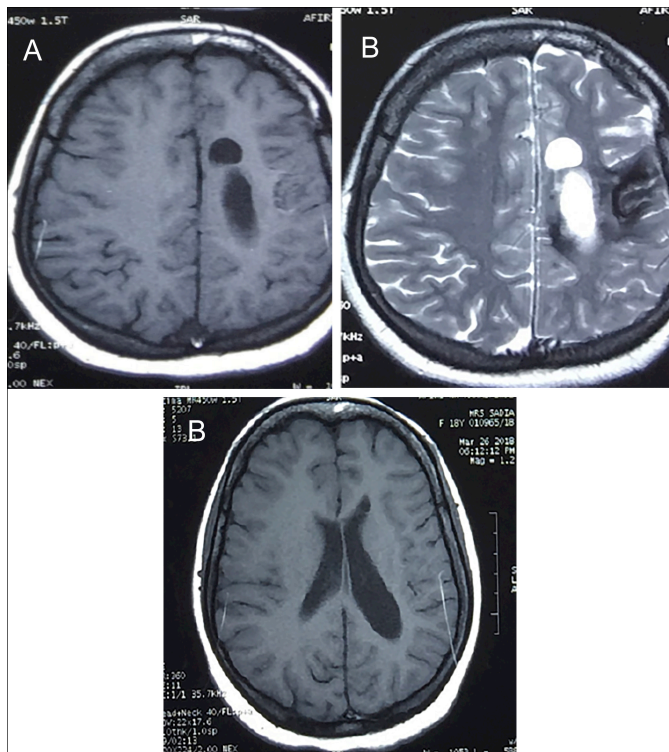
(A) Axial T1-weighted MRI showing left-sided CSF intensity cystic lesion adjacent to the frontal horn of ventricle, and focal cortical atrophy of parietal lobe. (B) Axial T2-weighted MRI showing left-sided CSF intensity cystic lesion adjacent to the frontal horn of ventricle, and focal cortical atrophy of parietal lobe with white matter changes. (C) Ex vacuo dilatation of left lateral ventricle compared to the right due to atrophy.
